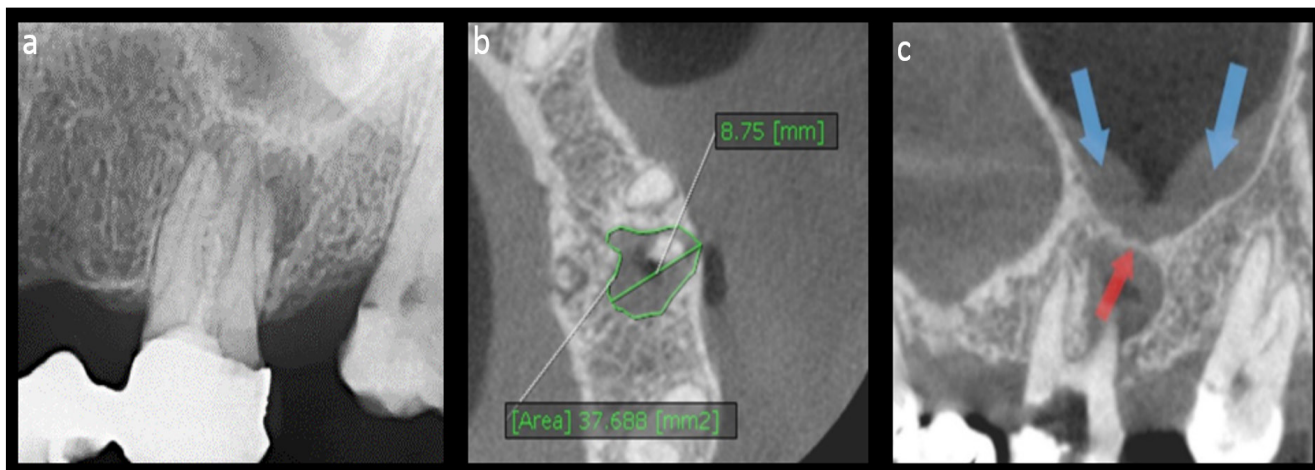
a) Radiographically visible periapical lesions on tooth 2.6. (CBCTPAI score – 4). b) The axial section shows a maximum periapical lesion diameter of 8,75 mm and a calculated area of 37,688 mm². Also, the vestibular cortical bone perforation can be observed (red arrow), (CBCTPAI score – 5 with variable “D”). c) On sagittal section can be observed the closeness of the lesion to the maxillary sinus (red arrow) and the consequent inflammation of the Schneiderian membrane (blue arrows).
